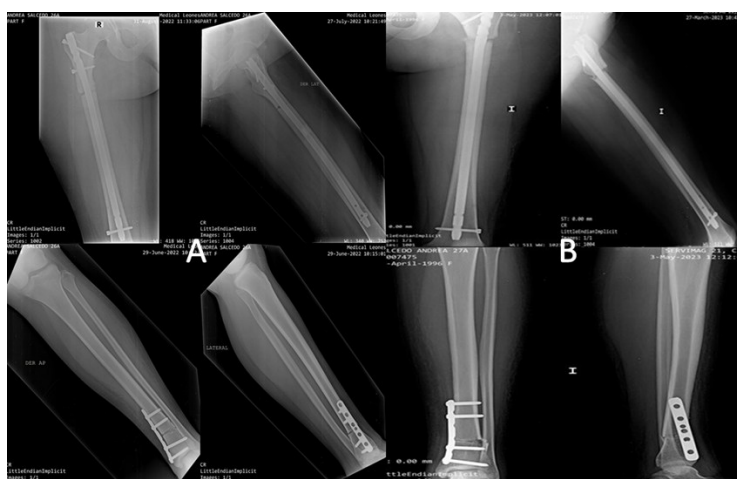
Postoperative radiographic studies of the lower extremity
